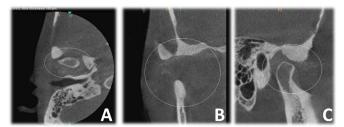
CBCT-A. Axial view. B. Coronal view. C. Sagittal view.
